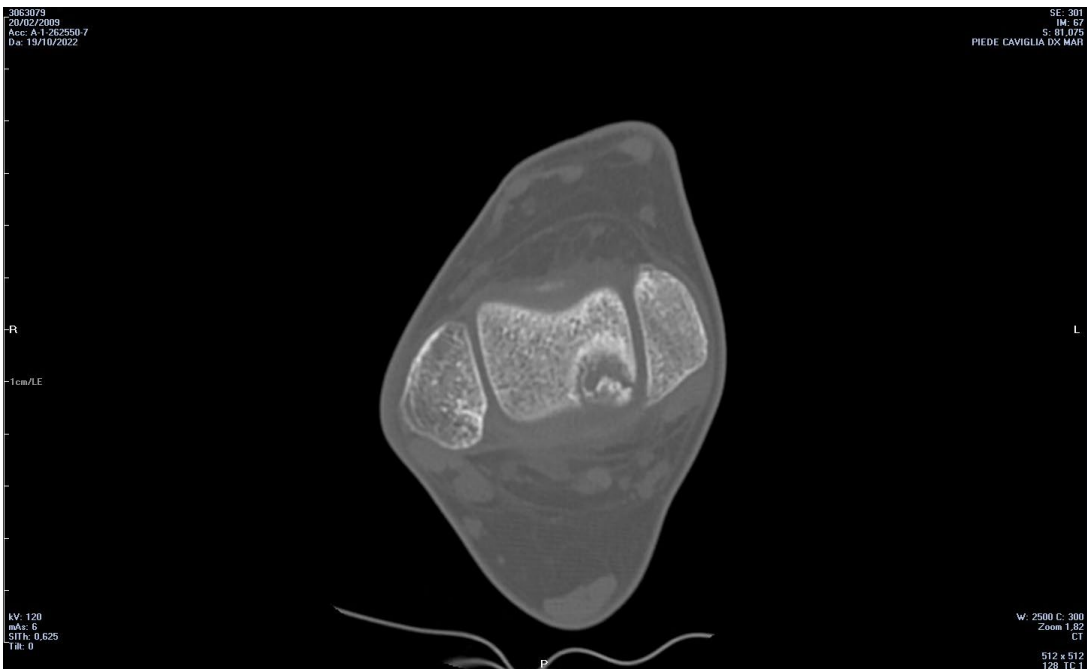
CT scan in coronal plan of patient with OLT
